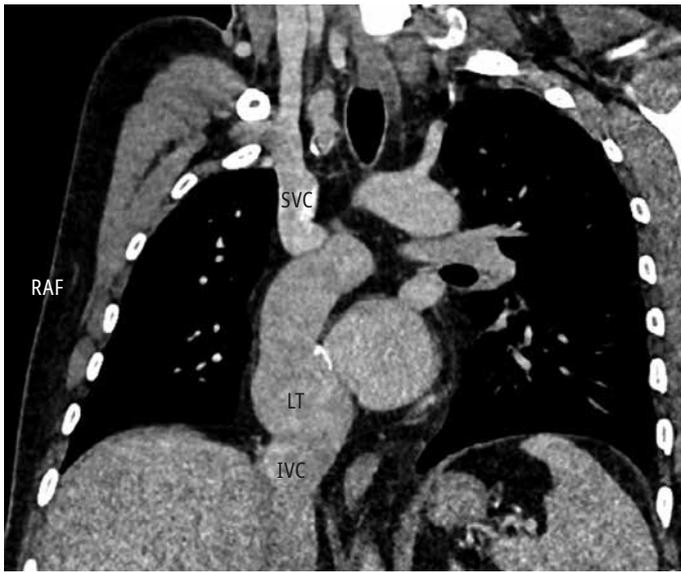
Computed tomography: a coronal reformat image showing the lateral tunnel of the total cavopulmonary connection
